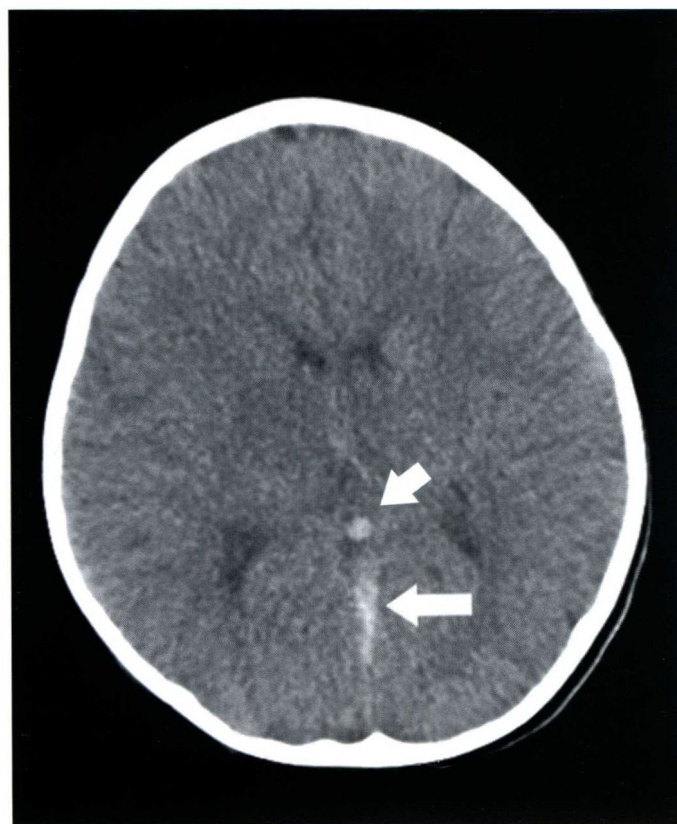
Axial CT shows thrombosis of the straight sinus (arrow) and the vein of Galen (short arrow) with associated hypoattenuation in the bilateral thalami.
